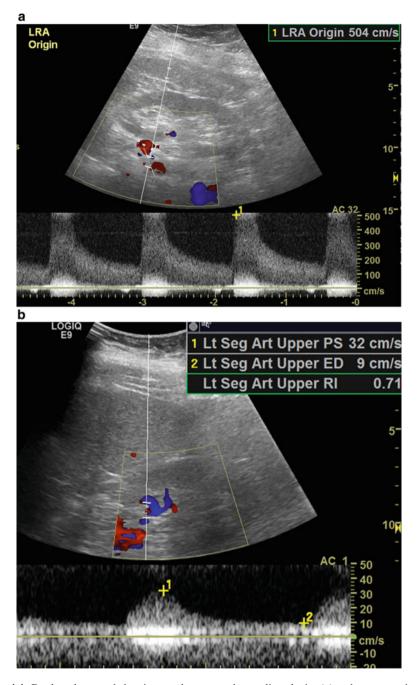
Duplex ultrasound showing renal artery peak systolic velocity (a) and parvus tardus in left segmental artery (b): a shows elevated peak systolic velocity of more than 500 cm/s of the left renal artery (LRA). PSV levels above 180–200 cm/s translate into more than 60 % lumen occlusion and are considered "hemodynamically significant." b demonstrates parvus tardus (*arrow*), note the slope of the systolic upstroke and absence of early systolic peak associated with diminished amplitude of the waveform
